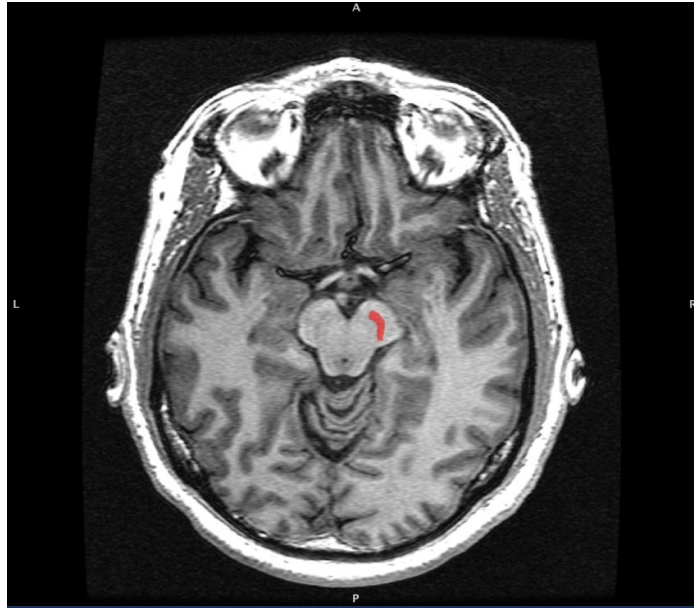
Axial MRI (T1W) slice with highlighting indicating location of the substantia nigra .
